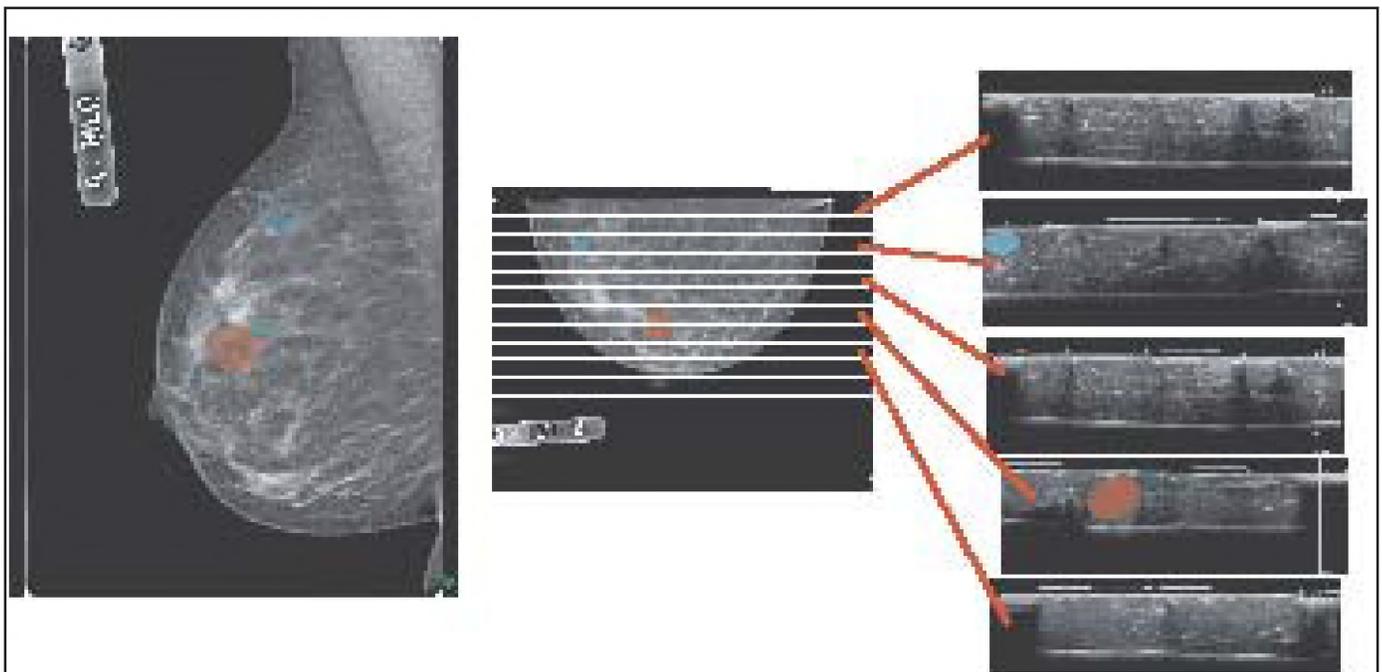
Co-registration of SIMULTANEOUS digital mammography and sequential parallel high resolution DICOM3 medical image format breast ultrasound.
